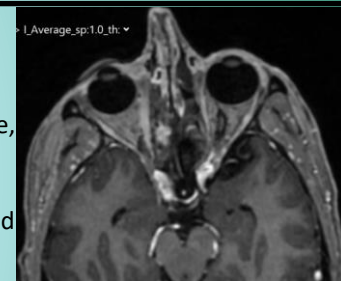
Most recent MRI showing no disease
